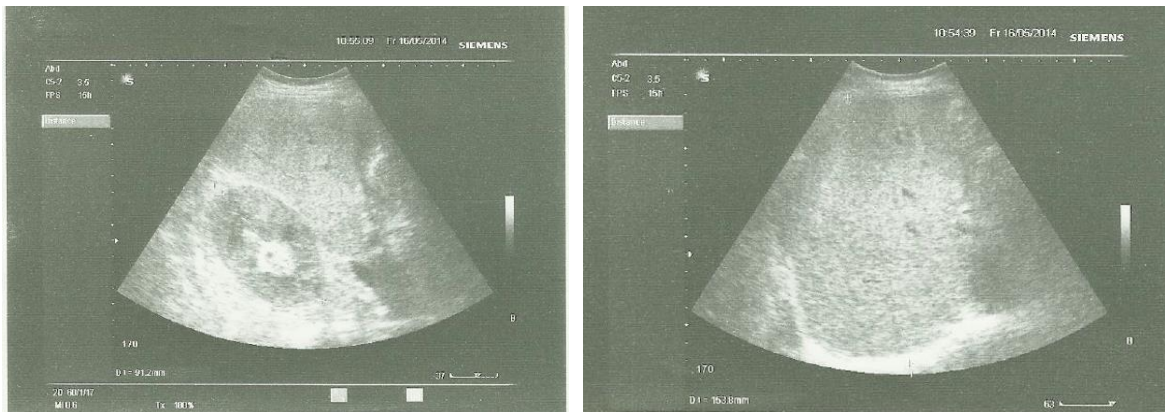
2D ultrasound images of liver and right kidney showing no structural abnormalities.
